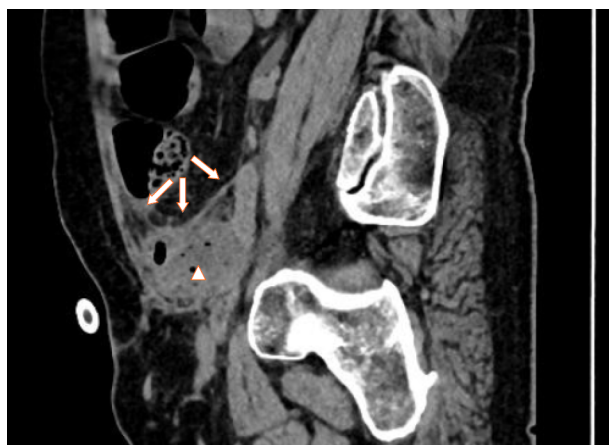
Three-dimensional computed tomography reconstruction showing the primary and secondary abscesses. A: Transverse view; B: Sagittal view; C: Coronal view. The primary focus is located at the baseline center, the white arrows indicate the vas deferens, and the arrowheads show the secondary focus.
